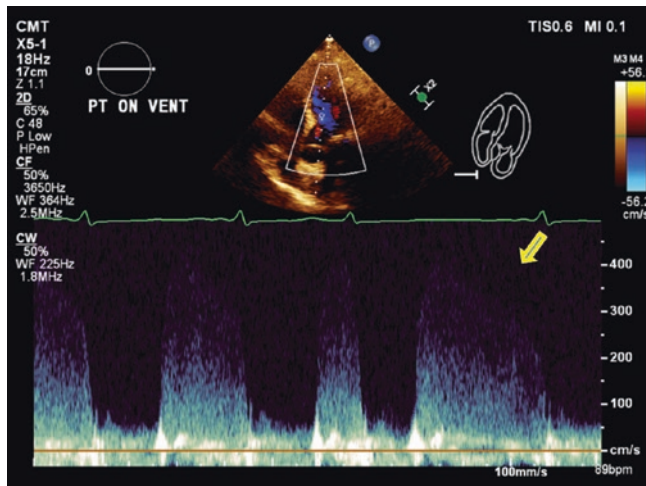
Spectral Doppler envelope of the aortic regurgitant flow. The arrow points the faint upper part of the envelope. Note, the rhythm is atrial fibrillation and the deceleration slope is therefore variable and the peak aortic regurgitant velocity is difficult to discern
